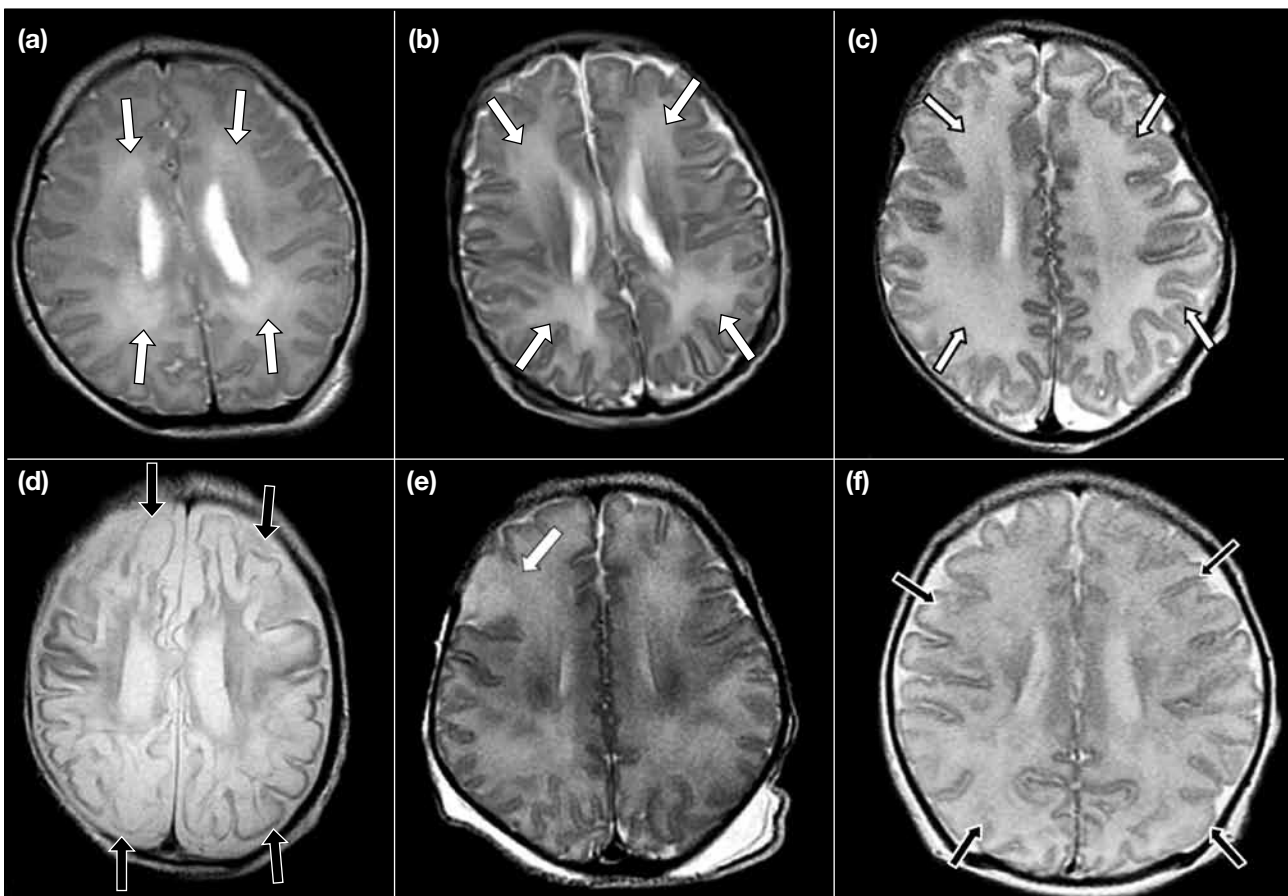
Fast spin-echo T2-weighted magnetic resonance imaging of the white matter (arrows) showing (a) normal signal, (b) mild, (c) moderate, (d) severe, (e) focal, and (f) diffuse signal abnormalities.
